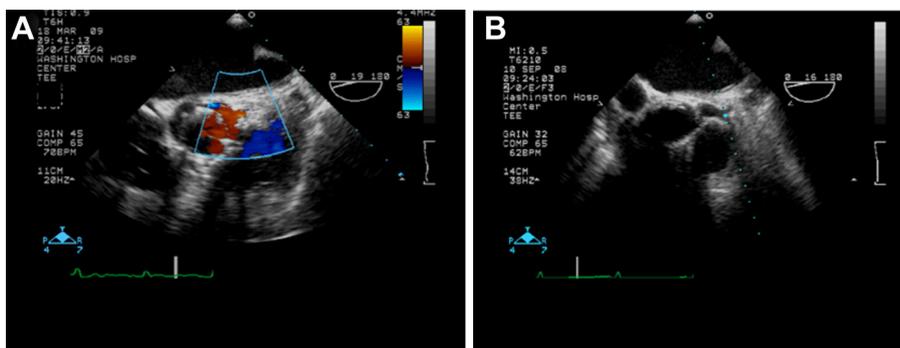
(A) Pulse-wave Doppler sample positioned over the portion of the left main coronary artery (B).
